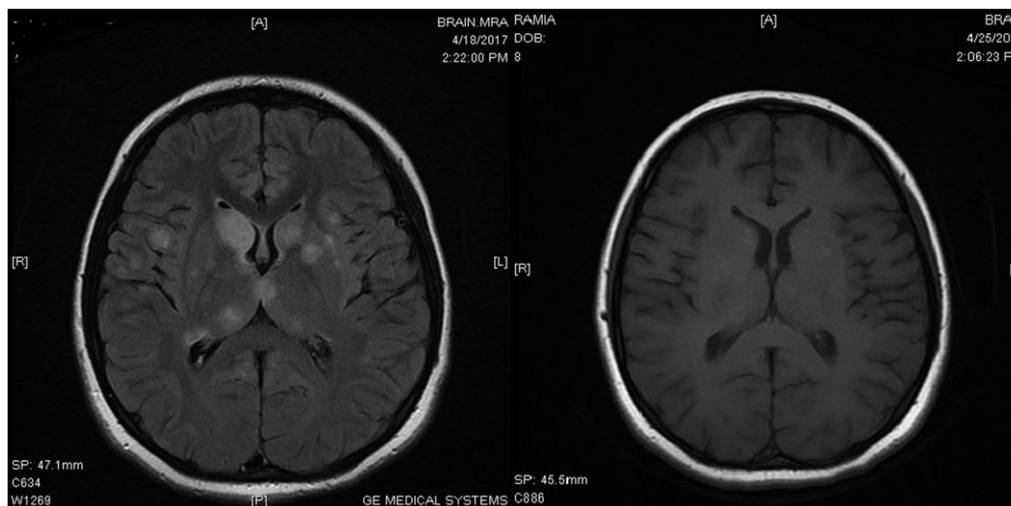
Comparison of MRI before and after 1 week treatment.
